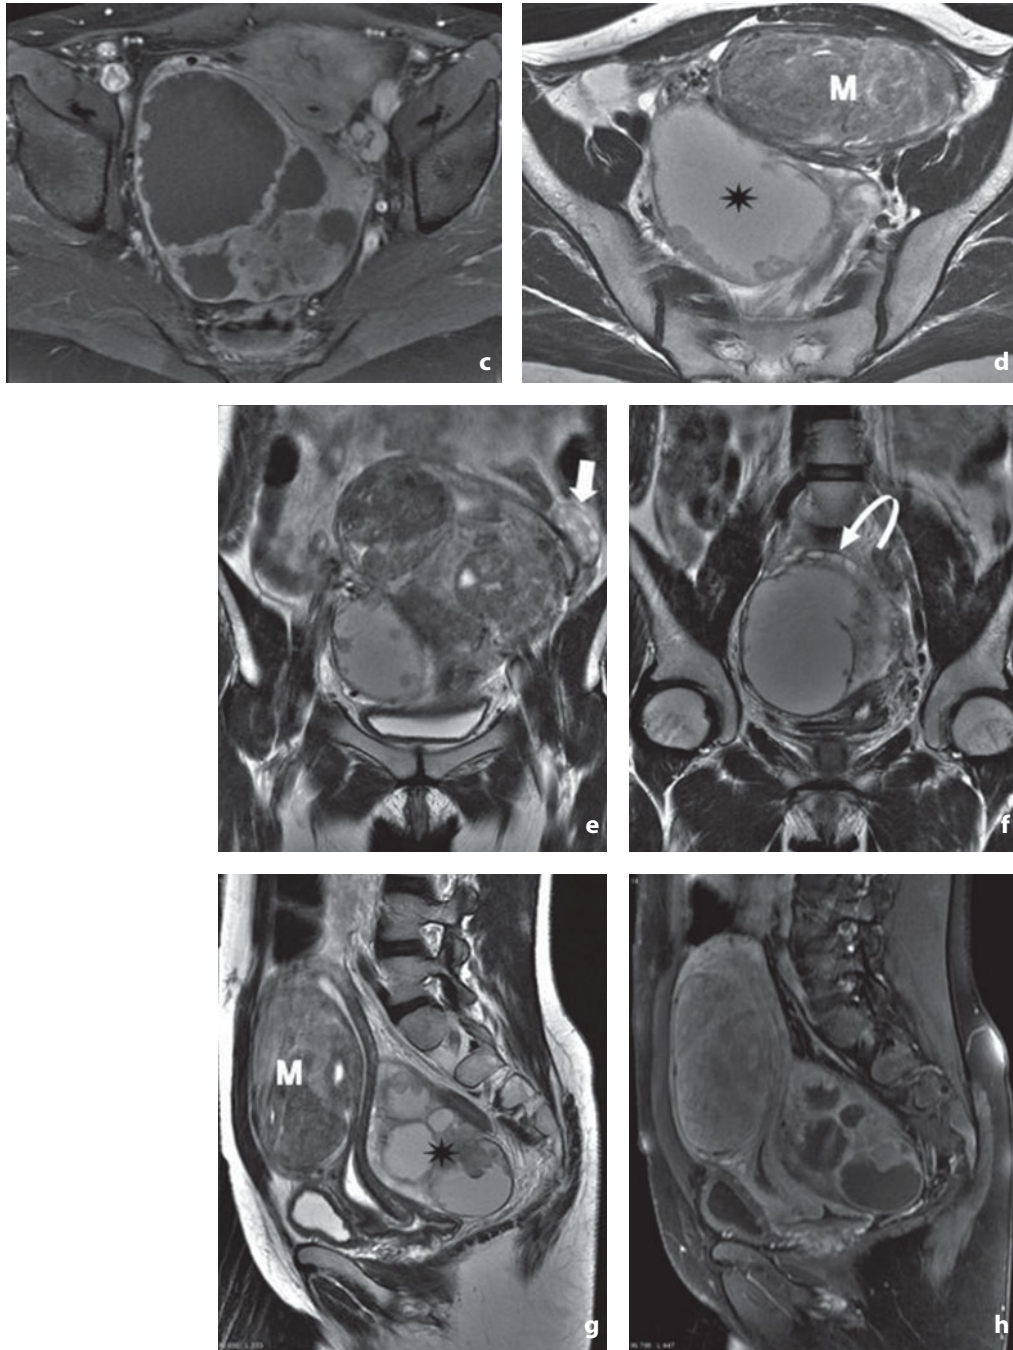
(cont.) c Axial fat saturated contrast-enhanced T1-weighted image shows marked enhancement of the septations and the solid nodules. d Axial T2-weighted image more cranial than the previous images. In front of the ovarian malignancy (*asterisk*) two large oval-shaped solid and heterogeneous expansive lesions can be identified attributable to uterine myomas (*M*). e Coronal T2-weighted image shows the left ovary (*arrow*) shifted cranially and laterally. f Coronal T2-weighted image better depicts the residual right ovarian parenchyma with several follicles pushed to the periphery (*curved arrow*). g Sagittal T2- and h T1-weighted images with fat saturation after contrast medium administration. The uterus is deformed and compressed by both the leiomyomas (*M*) and the ovarian malignancy (*asterisk*)
